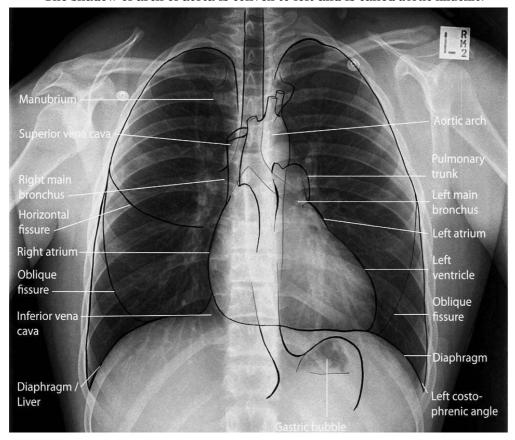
Plain radiograph of thorax. The cardiac area, aortic knuckle (shadow of arch of aorta) and shadows of domes of diaphragm have been marked.
